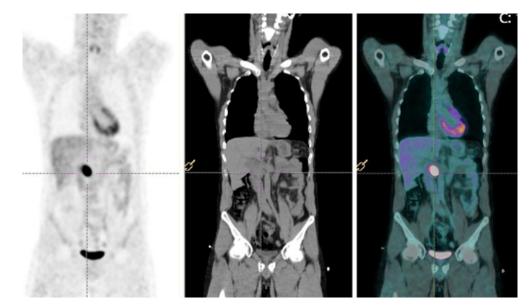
¹⁸F-FDG PET/CT scan revealing hypermetabolic mass below the right renal artery.
